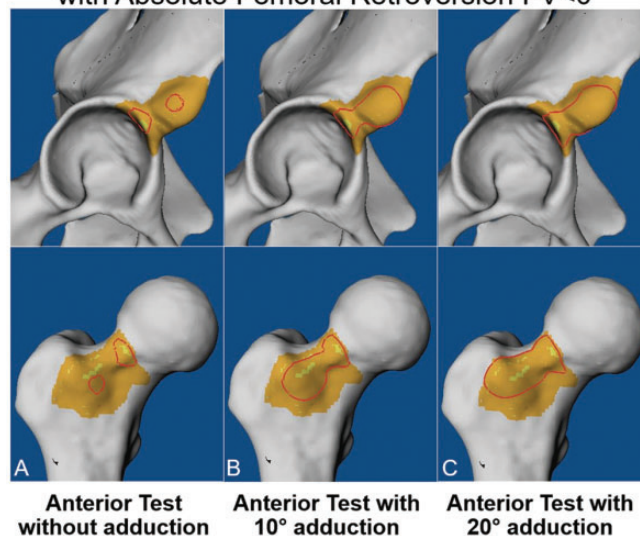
Determining the location of acetabular (top row) and femoral (bottom row) hip impingement during the FADIR test at 90° of flexion and 30° of internal rotation combined with (A) 0° , (B) 10° , and (C) 20° of adduction on computed tomography scans from a 23-year-old man with absolute femoral retroversion. The impingement area is outlined in red. FADIR, flexion, adduction, internal rotation.
